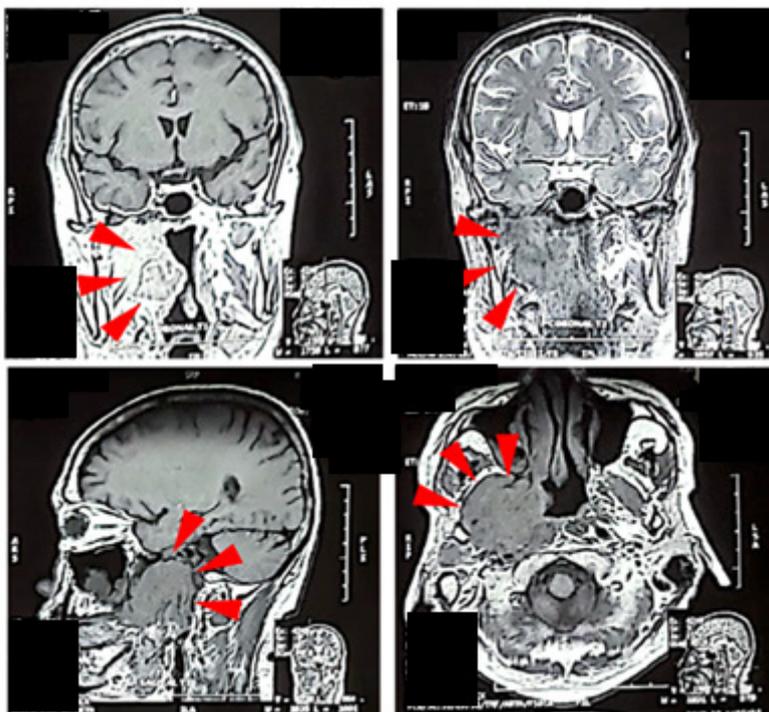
1.5 T MRI results. The red arrow showed inhomogeneous solid mass appeared in the right nasopharyngeal mucosal space which extend to the right parapharyngeal space, right carotid space, right retropharyngeal space, right masticator space, right oropharyngeal mucosal space, right hard palate and destroy posterior wall to the right maxillary sinus.
